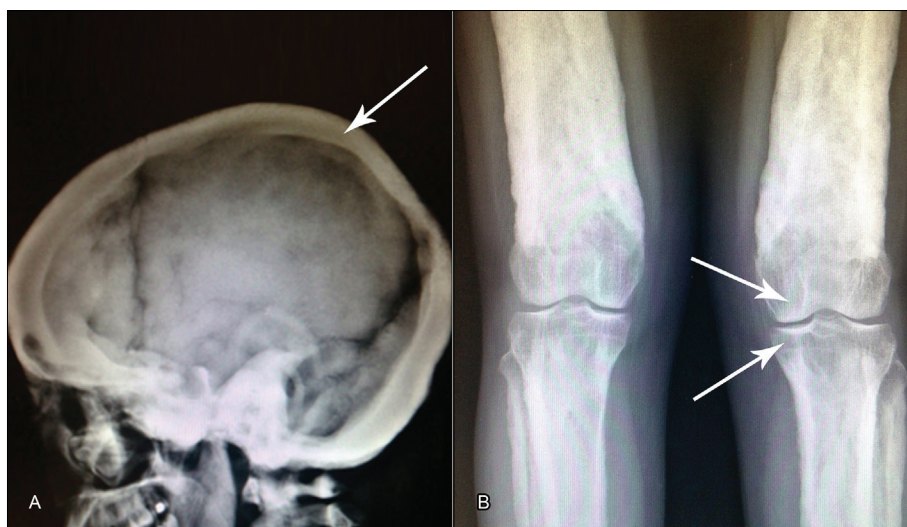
A. Radiography of skull in profile. Note the diffuse cortical thickening of the skull cap (arrow). B. Radiography of the knees in anteroposterior view. Preservation of the cortical thickness of the epiphyses of the femurs, tibias and fibulae (arrows) is observed.
